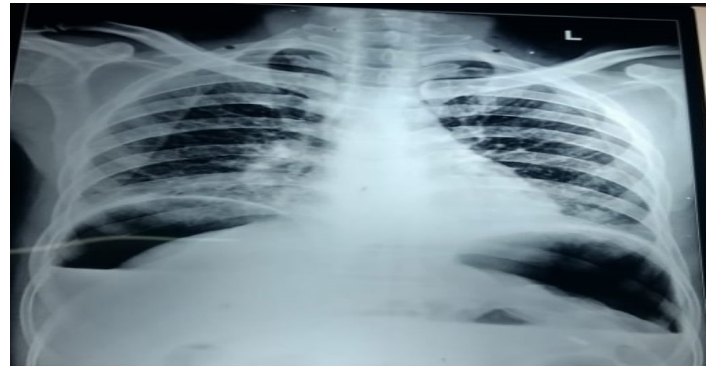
Xray Chest and upper abdomen showing free gas under both domes of diaphragm in a case of peptic perforation.
